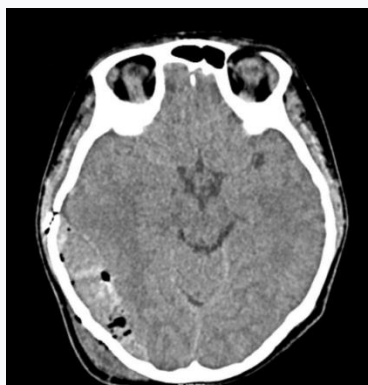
Axial CT slice of a non-contrast MSCT head scan with finding of an EDH
